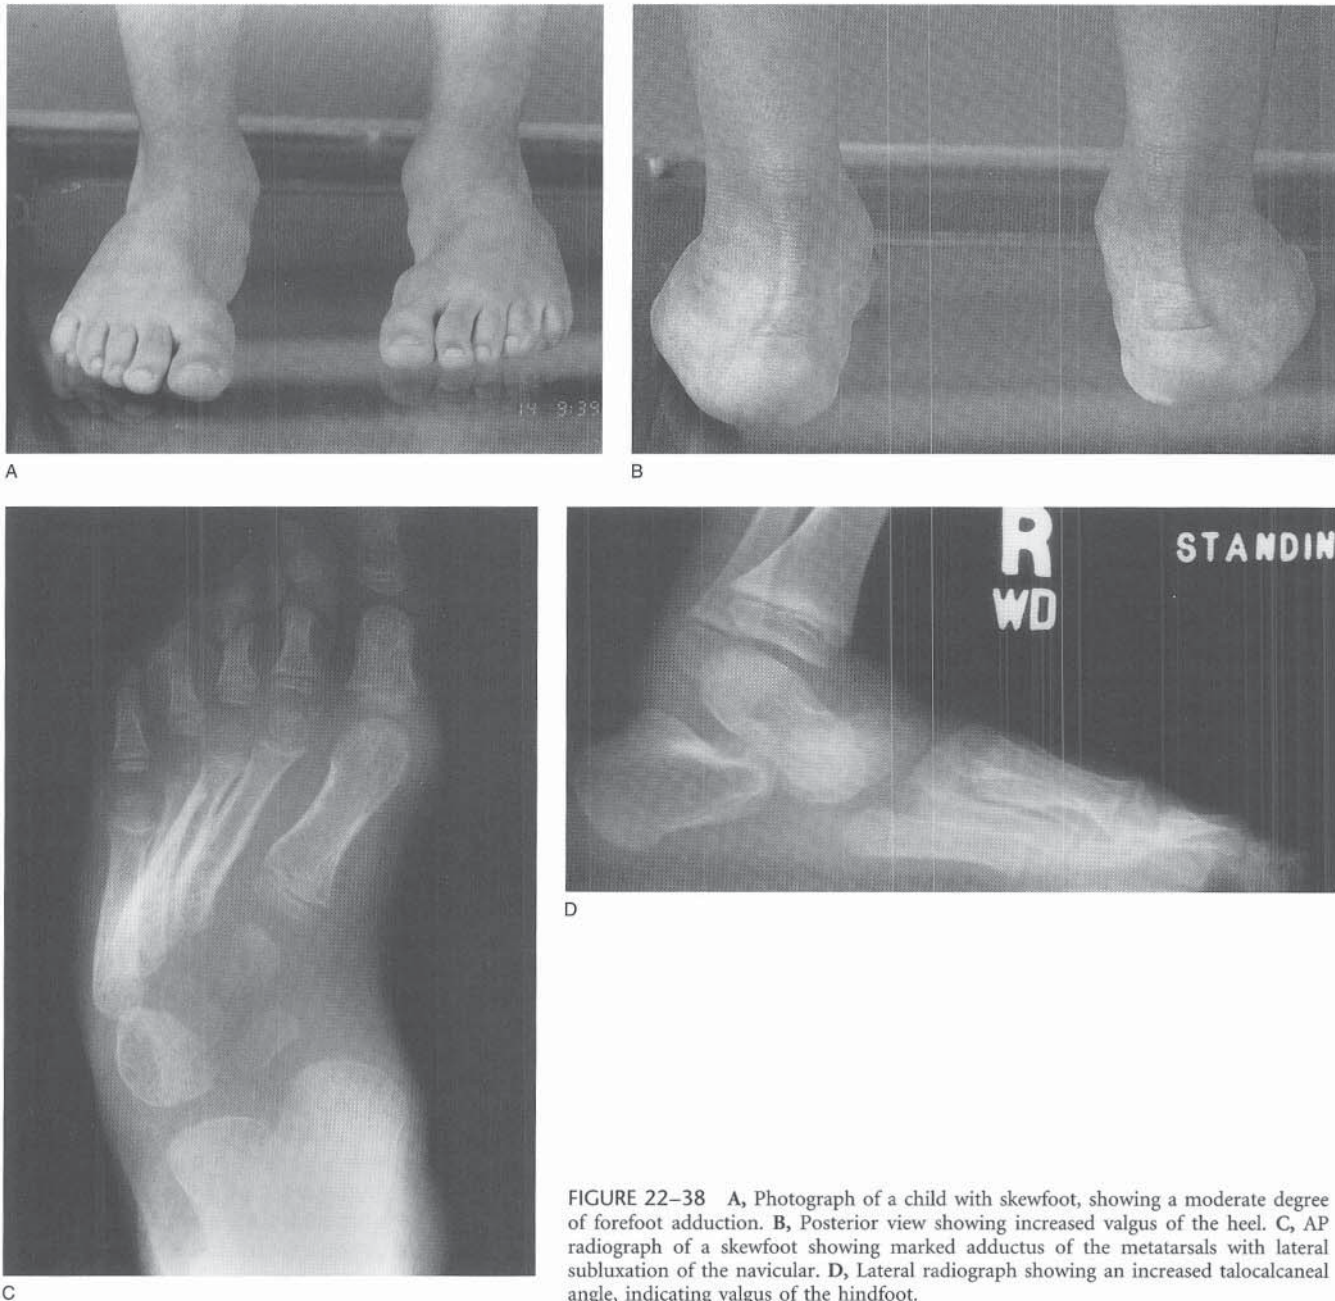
A, Photograph of a child with skewfoot, showing a moderate degree of forefoot adduction. B, Posterior view showing increased valgus of the heel. C, AP radiograph of a skewfoot showing marked adductus of the metatarsals with lateral subluxation of the navicular. D, Lateral radiograph showing an increased talocalcaneal angle, indicating valgus of the hindfoot.
